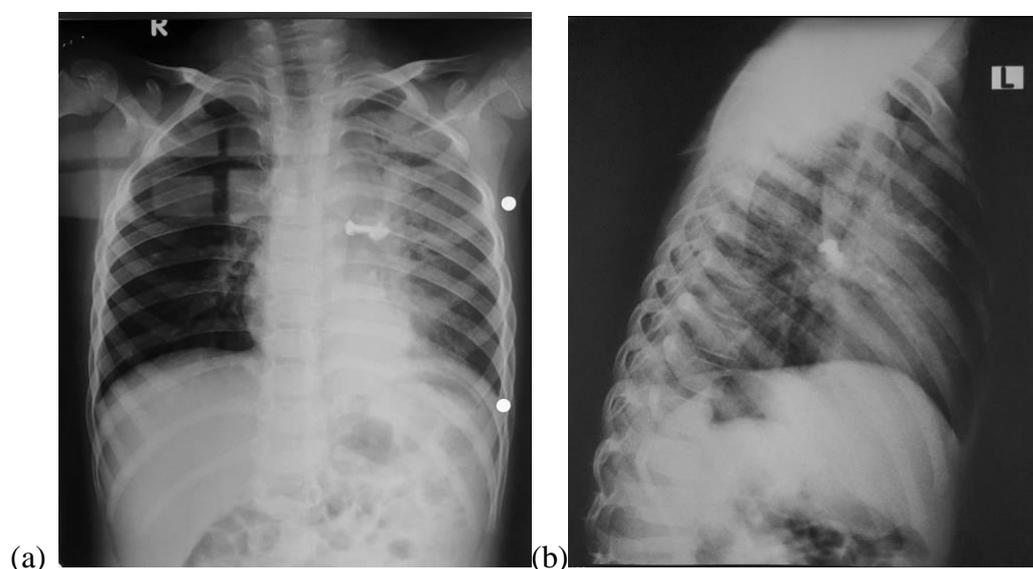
Chest X-ray: anteroposterior view (a) left lateral view (b) Pneumonia in the left lung has not clearly improved. A projected opaque shadow of metal density (screw/ foreign body) in the left paravertebral (T5-T6).
